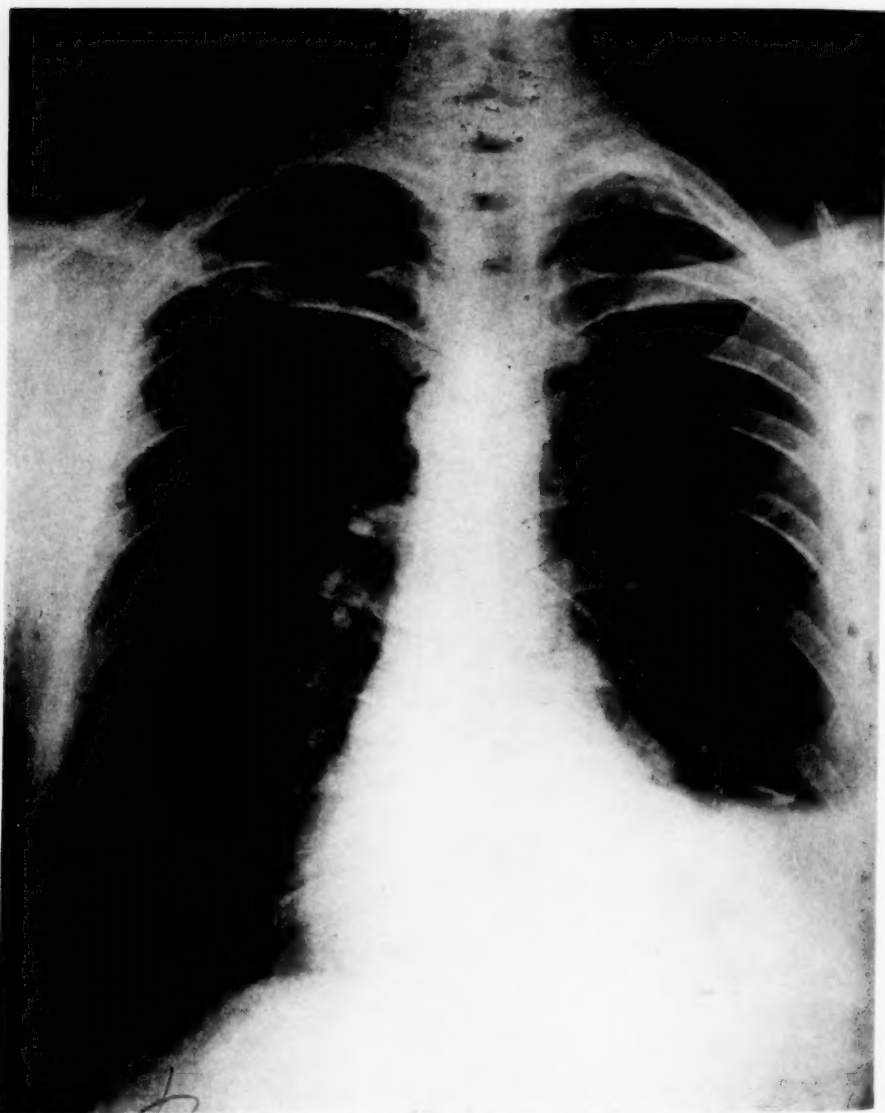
Roentgen-ray following almost complete evacuation of fluid from chest showing normal lung fields.
